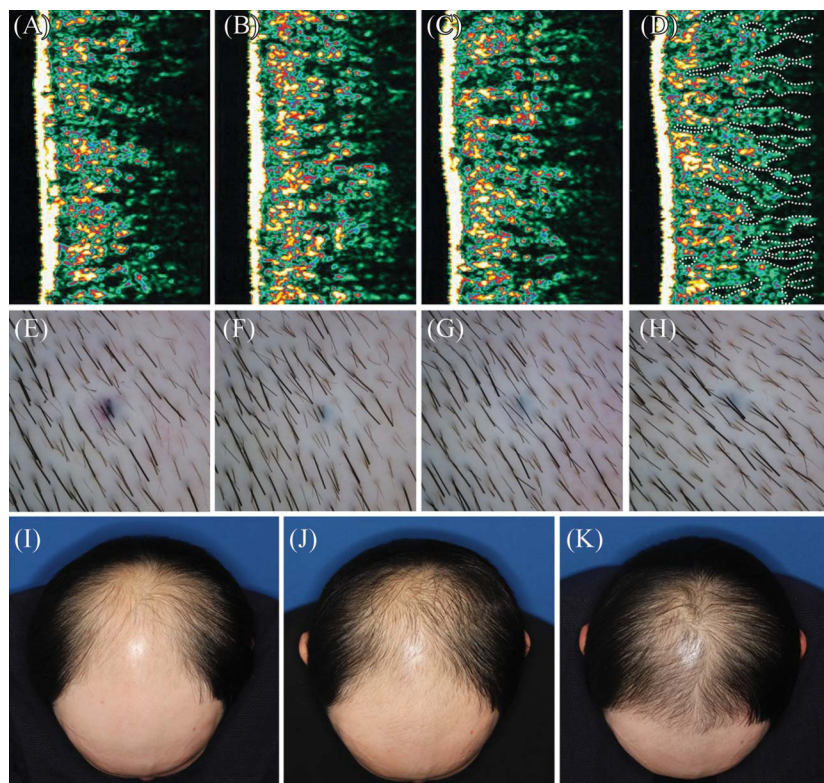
A 33-year-old man treated with ADSC-CM injection and oral finasteride. Upper row shows cross-sectional ultrasonographic images of the right scalp at T0 (A), T2 (B), T4 (C), and T6 (D). Dermal thickness increased from 2.05 mm (A) to 2.19 mm (D). Dermal echogenicity increased from 28.6% (A) to 32.2% (B), then decreased to 31.1% (D). Dotted line represents hair follicles (D). Middle row shows trichoscopic images of the right scalp at T0 (E), T2 (F), T4 (G), and T6 (H). Hair density increased from 159.5/cm² (E) to 176.3/cm² (H). Lower row shows clinical photographs at T0 (I), T6 (J), and 1 year after 10 sessions of treatment (K). ADSC-CM, adipose-derived stem cell-conditioned medium.
